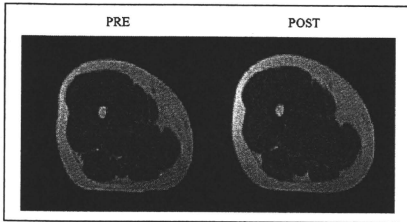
Typical magnetic resonance images of the right side of mid-thigh taken before (PRE) and after (POST) the 10-weeks walk training with blood flow reduction (participant NM).
